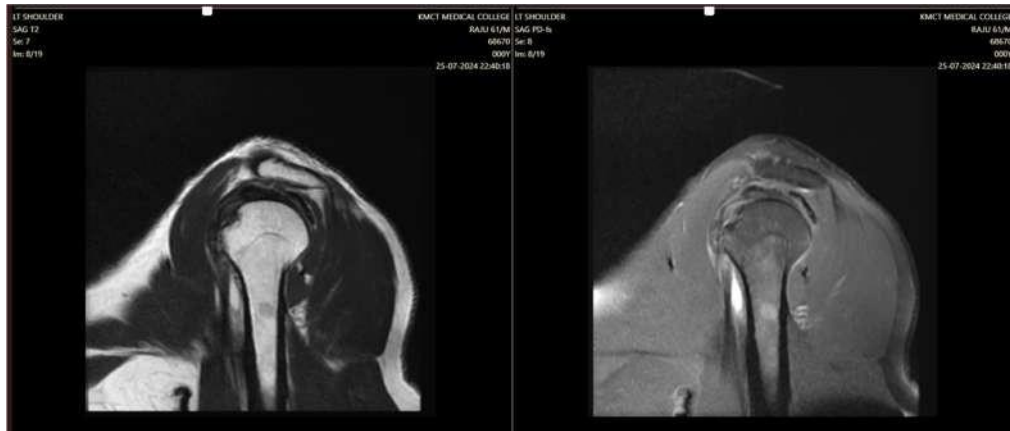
MRI image supraspinatus tendinosis
